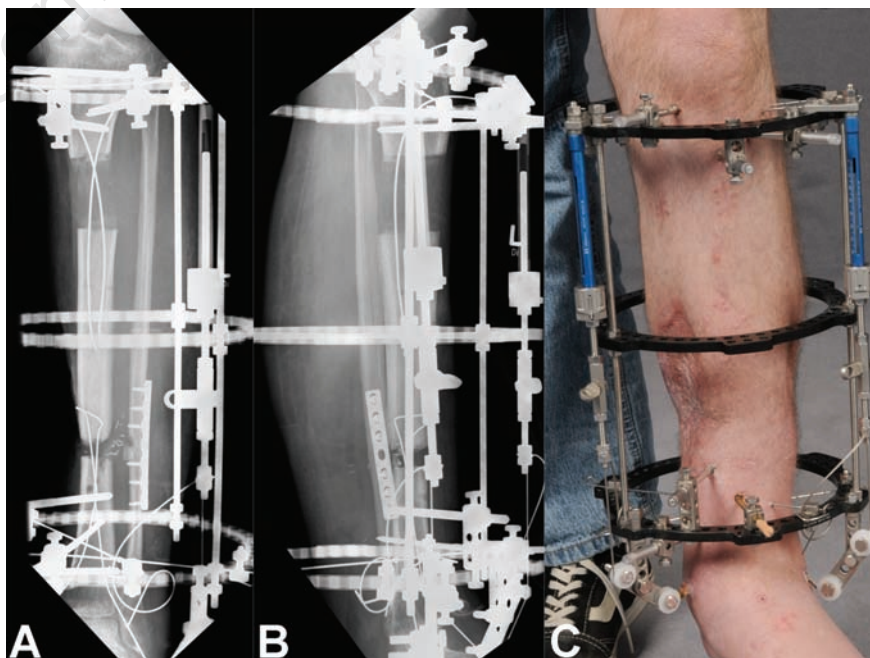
X-rays (A, B) of Patient 7 during the distraction phase (anterograde bone segmental transport) and clinical picture (C) of the Ilizarov external frame with the applied cable system and transport clickers.
